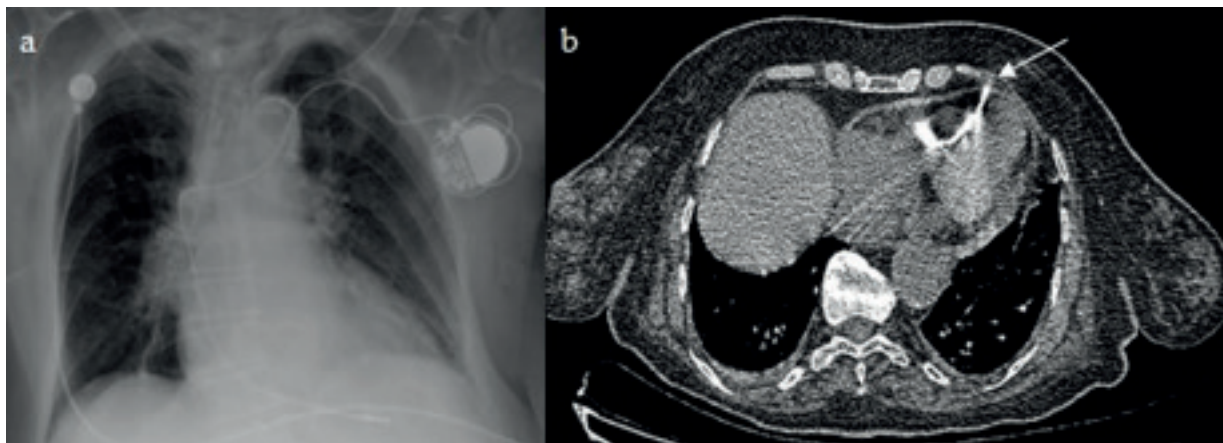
Chest X-ray showing the position of the pacemaker lead (a), and computed tomography showed that the tip of the lead had perforated the right ventricular apically and extended into the pericardium (arrow) (b).
